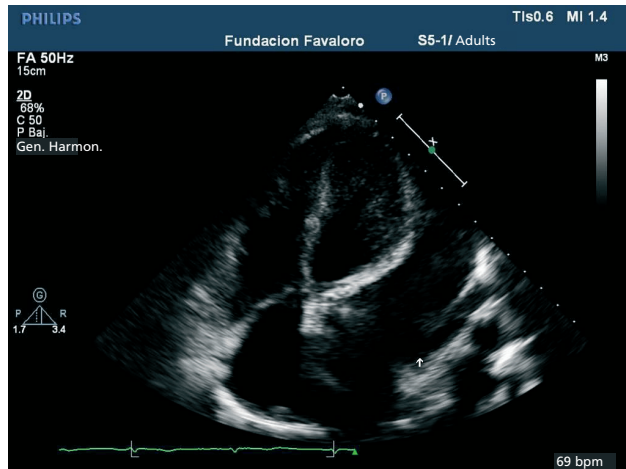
Four-chamber view transthoracic echocardiography showing giant aneurysm of the left atrial appendage, close to the left ventricle.
